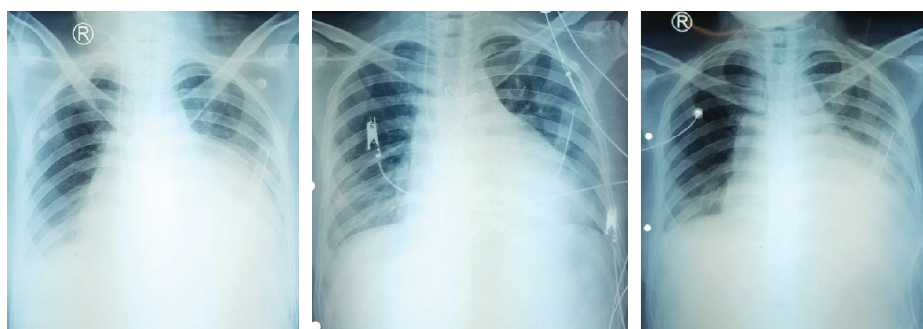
Chest Xray After Pericardiectomy (A), Post-operative Day 5 (B), and Post-operative Day 10 (C)
